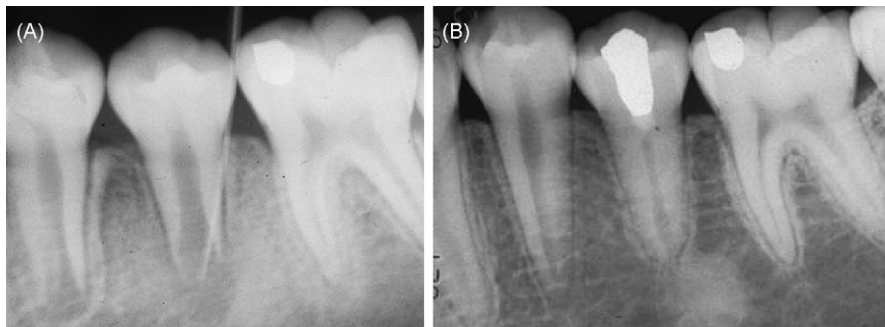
Clinical case of a 10-year-old patient. (A) Radiograph showing an immature root of tooth #29 with an open apex and an extensive radiolucency at the periapical and mesial regions of the root. (B) Seven months after the initial treatment showing complete maturation of the root apex, healing of the periradicular bone, a significant increase of the calcified tissue in the root, a significant decrease of root canal space, and the calcified coronal third of the root canal. The pulp chamber and the accessed space were filled with Cavition and Ketac silver, respectively. (Adapted from the original article with approval.<sup>19</sup>)
